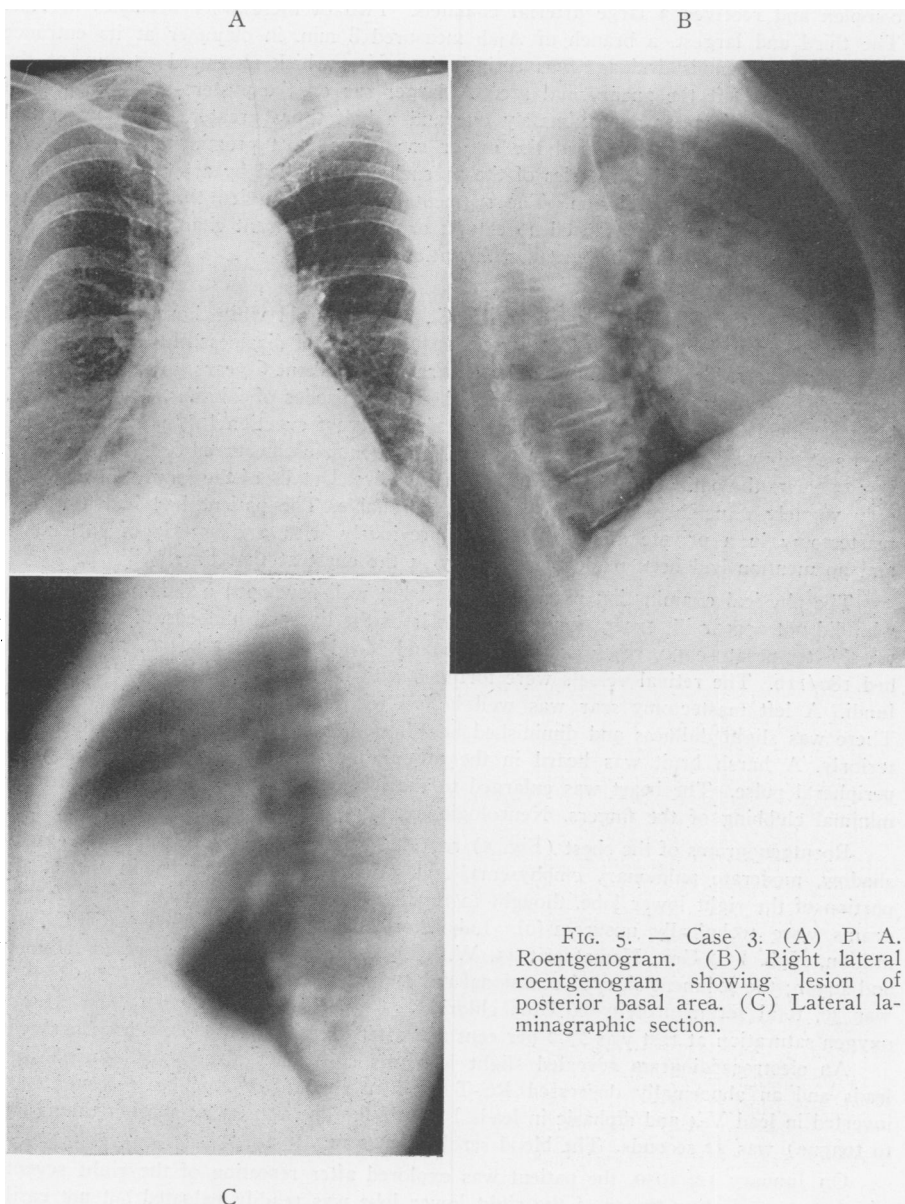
Case 3. (A) P. A. Roentgenogram. (B) Right lateral roentgenogram showing lesion of posterior basal area. (C) Lateral laminagraphic section.
